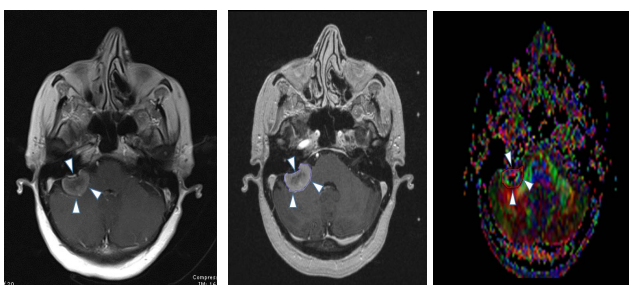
Right cerebellopontine angle meningioma at pre-treatment stage on postcontrast axial T1-weighted image (arrowheads) (a). In follow-up MRI, 29 months after radiosurgery, an increase in tumor volume is observed (arrowheads) (b). ROI placement (arrowheads) is seen on the FA map to calculate DTI parameters (c). (A higher resolution / colour version of this figure is available in the electronic copy of the article).
